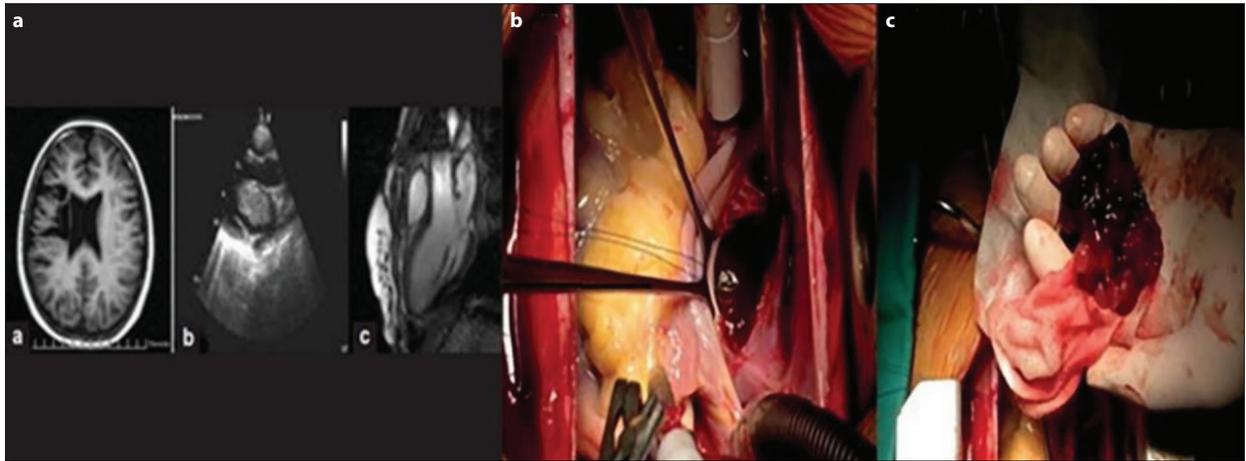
Preoperative and intraoperative myxoma findings; a – preoperative brain and heart computed tomography scans of a huge myxoma in a patient with Carney complex; b – intraoperative finding of a myxoma; c – the tumorous mass after enucleation
